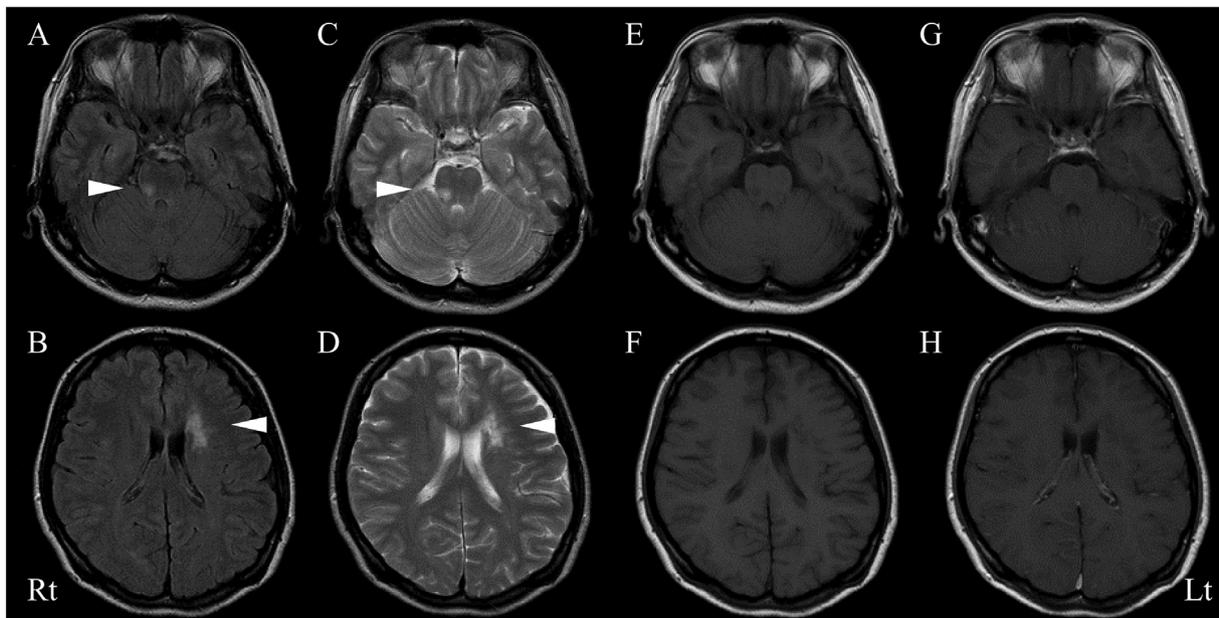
Head MRI (GE, 1.5 T) FLAIR (TR8000 ms, TE 119 ms) (A) and T2WI (TR 3500 ms, TE 90 ms) (C) showing a high signal intensity lesion in the upper right side of the pons. Head MRI gadolinium-enhanced T1WI (TR 665 ms, TE 14 ms) (G) showing partial contrast enhancement. Head MRI FLAIR (B) and T2WI (D) also showing high signal intensity in the left anterior horn of the lateral ventricle, the left thalamus and the putamen that was considered an old lesion.
